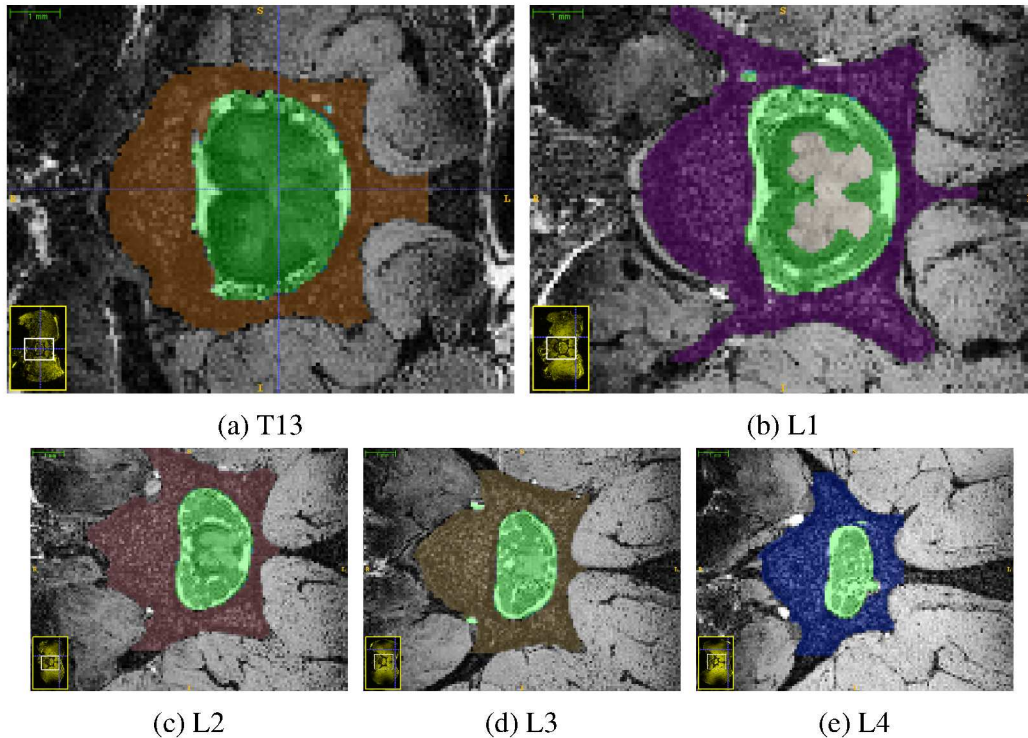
Transverse slices of the MRI data of the spinal cord of an adult female Sprague Dawley. Each subfigure shows a slice in the approximate middle of each vertebra: (a) T13 vertebra, (b) L1 vertebra, (c) L2 vertebra, (d) L3 vertebra, and (e) L4 vertebra. The CSF, white matter, gray matter, and nerve fibers are labeled green except for the L1 gray matter which is uncolored. The dorsal direction is to the right of the page.
